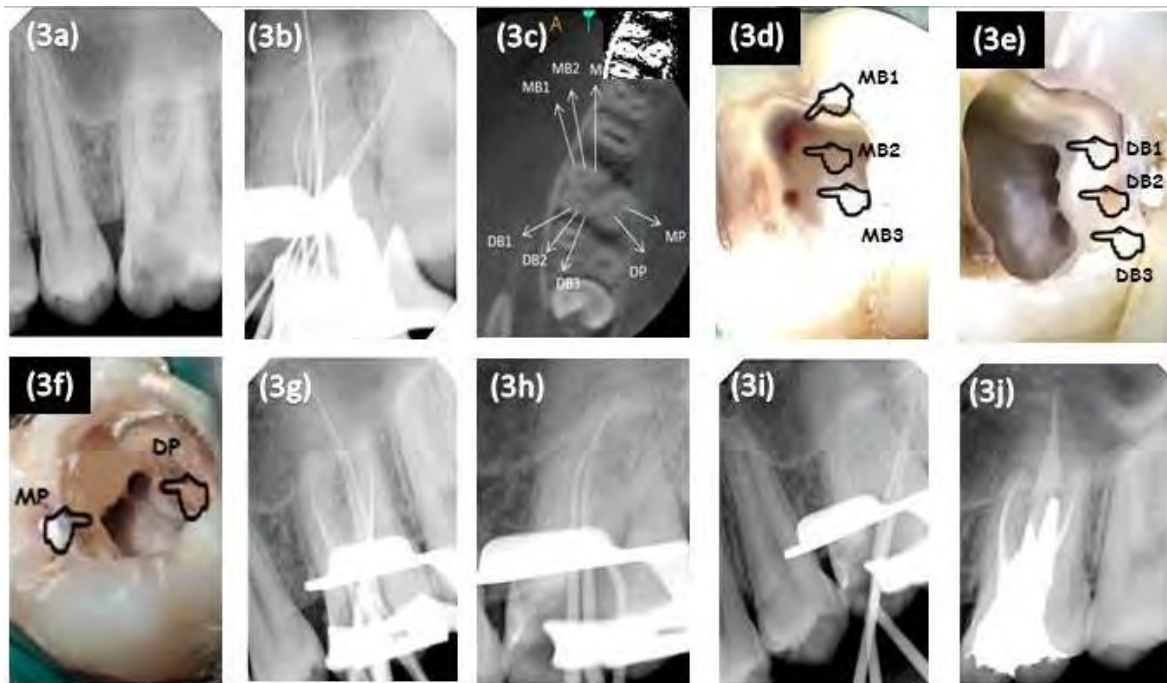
Tooth #16. (3a) Pre-operative IOPAR, (3b) WL IOPAR (3c) Pre-operative CBCT axial view, (3d , 3e, 3f), MB1, MB2, MB3, DB1, DB2, DB3, MP & DP canal orifices, (3g, 3h, 3i) Master cone IOPAR, (3j) Post-operative IOPAR
